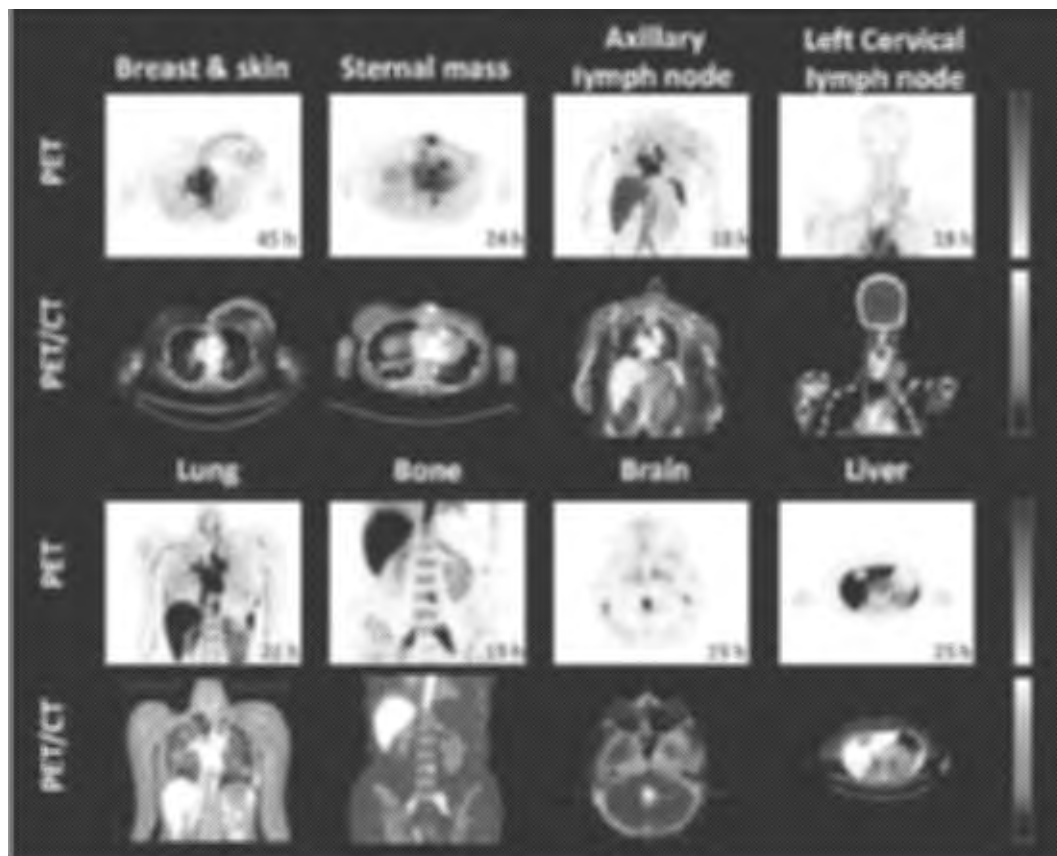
Visualization of ^{64}Cu -MM-302 lesion deposition. Representative PET and fused PET/CT images of ^{64}Cu -MM-302 in lesions at different anatomic locations. Intensity scale bars represent deposition from 0 to 10 %ID/kg (derived from $\text{SUV}_{\text{median}}$). The regions of interest used to measure tumor deposition of ^{64}Cu -MM-302 are shown in blue or turquoise outlines. ^{64}Cu -MM-302 uptake was detected at above muscle background level in lesions of various anatomic locations that are common for HER2-positive metastatic diseases.
